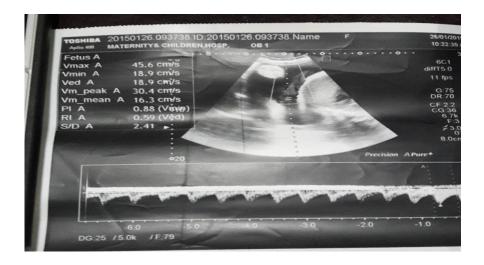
shows normalColor Doppler of the umbilical artery waveform at 29 Wks.
